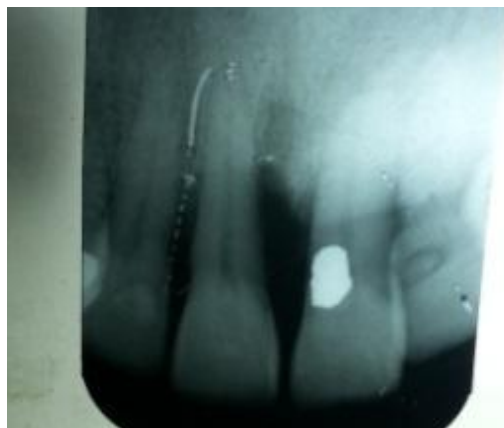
Pre-operative periapical radiograph shows the bone defect
